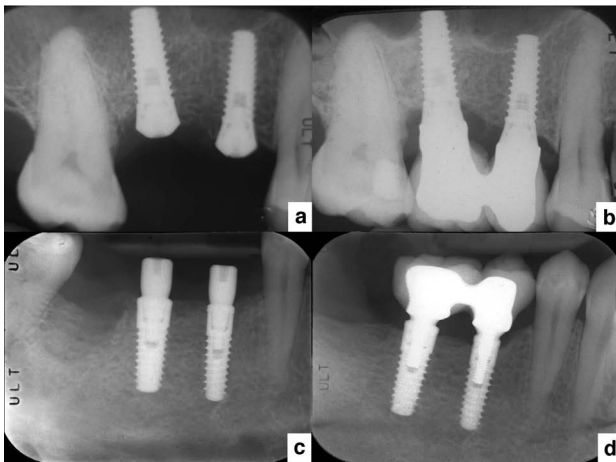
Radiograph of tapered implants
